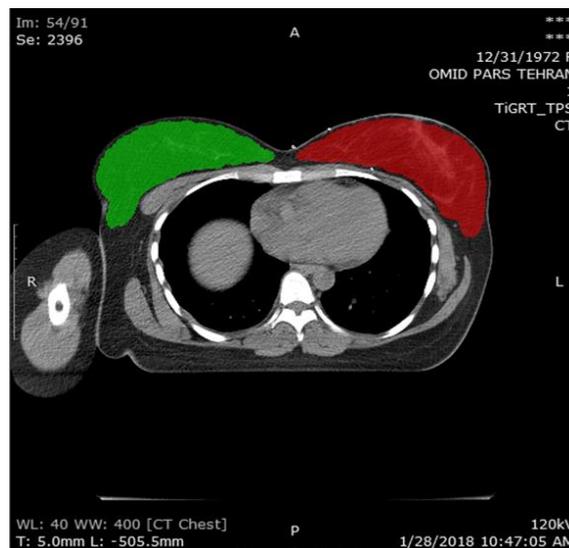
The ROI segmentation in CT images using Mazda software for extraction and analysis of radiomic features (red area: irradiated breast; green area: contralateral breast).
